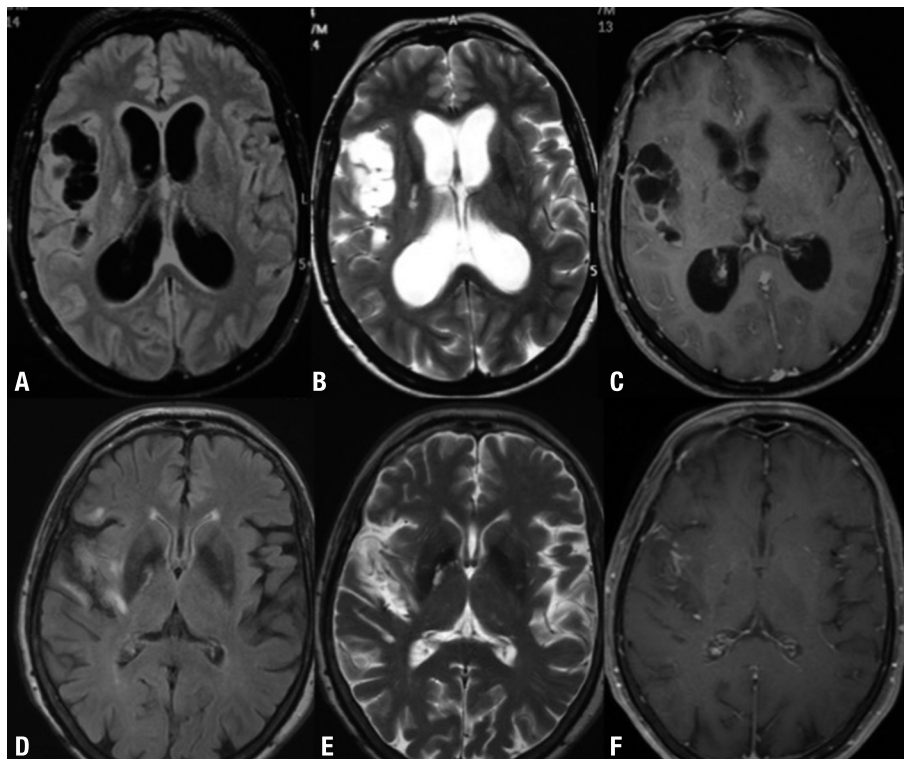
[A] Axial FLAIR, [B] Axial T2WI, [C] Axial T1W1 with gadolinium. [A, B] shows multiple cystic lesions without scolex in right Sylvian fissure. [C] gadolinium-enhanced MR image shows diffuse arachnoid enhancement surrounding the cysts. [D] Axial FLAIR, [E] Axial T2WI, [F] Axial T1W1 with gadolinium. [D, E and F] follow-up Brain MRI after second shunt replacement shows absence of hydrocephalus and slight enlargement of right Sylvian fissure. [F] slight enhancement in right Sylvian fissure, previously containing multiple cysts.
